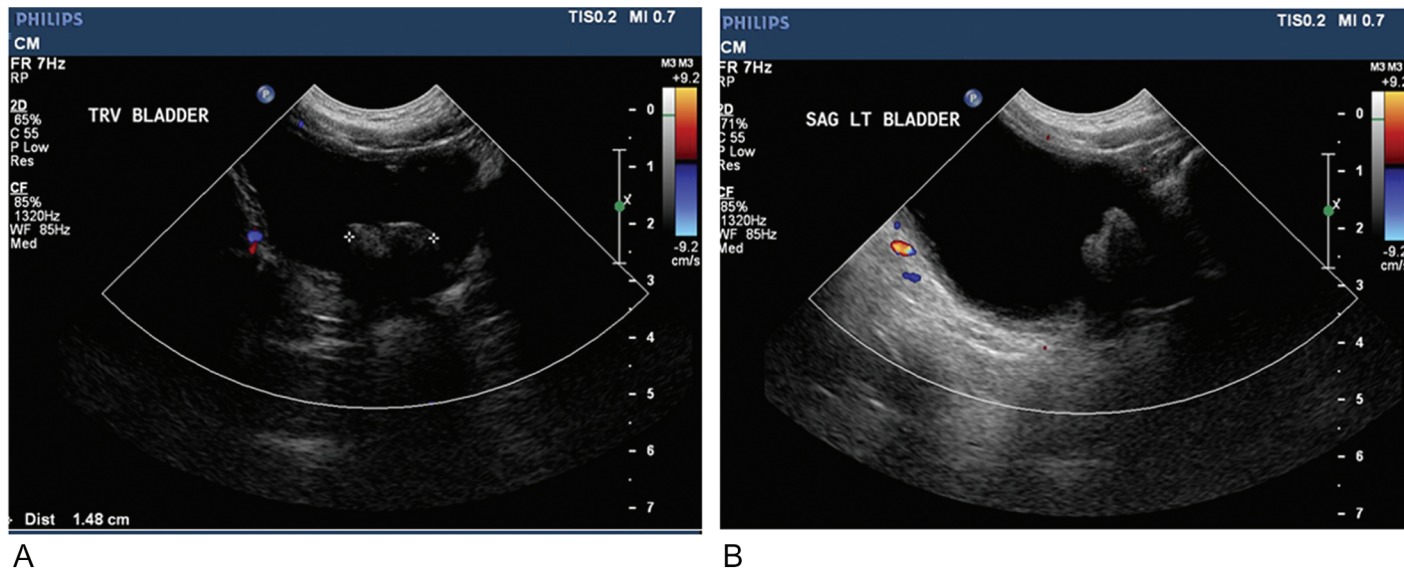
A, Transverse ultrasound image of 1.5-cm echogenic nonmobile lesion along the posterior bladder wall. B, Longitudinal ultrasound image of 1.5-cm echogenic nonmobile lesion at bladder neck.
